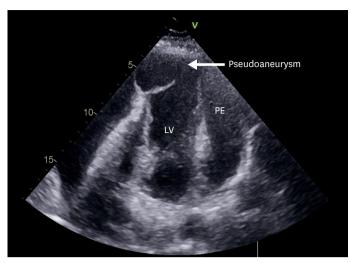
Modified apical 4 chambered view showing a large apical pseudoaneurysm originating from the LV with a narrow neck and thin walls. Massive PE can be seen surround the LV. LV: left ventricle, PE: pericardial effusion.
